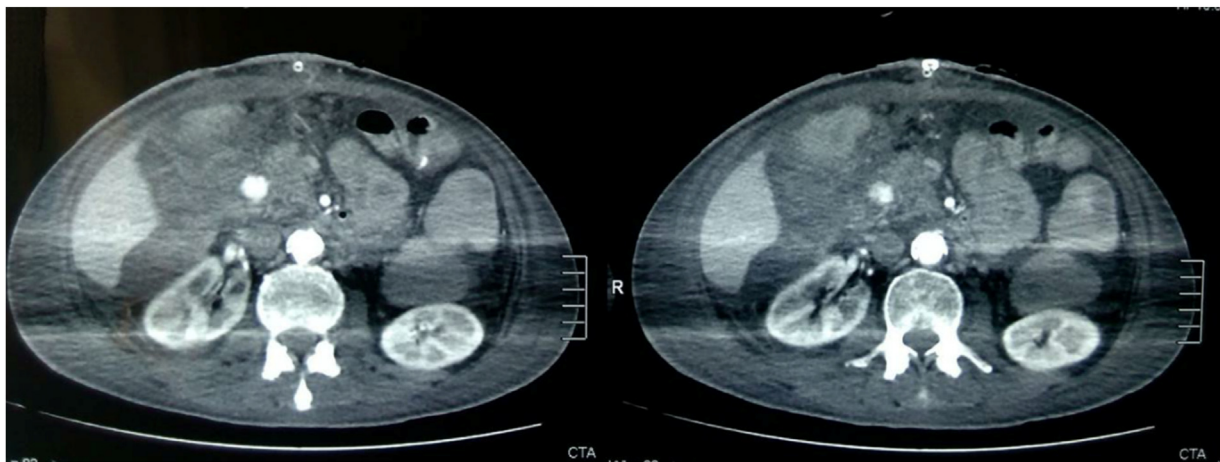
CTA 48 h later, where the pseudoaneurysm is obvious.
